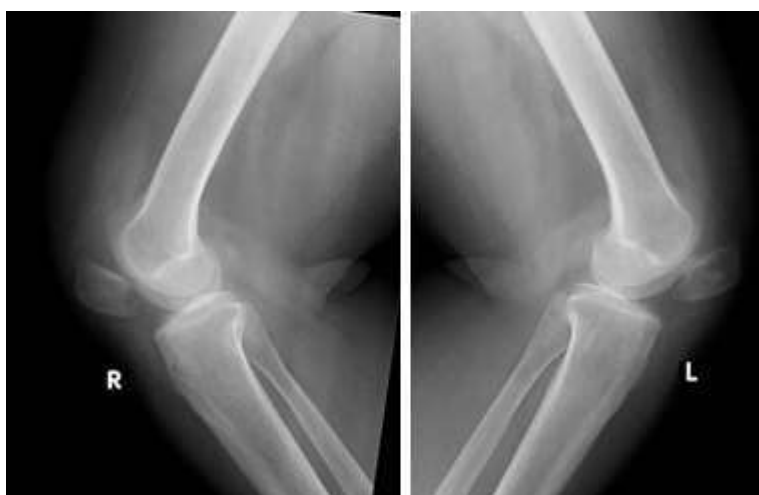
X-ray of both knees on lateral view showing low-lying patella
